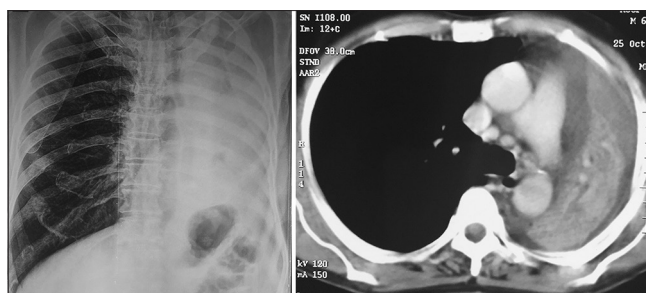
Chest radiograph (right panel) and computed tomography of the thorax (left panel) revealing complete collapse of the left lung
